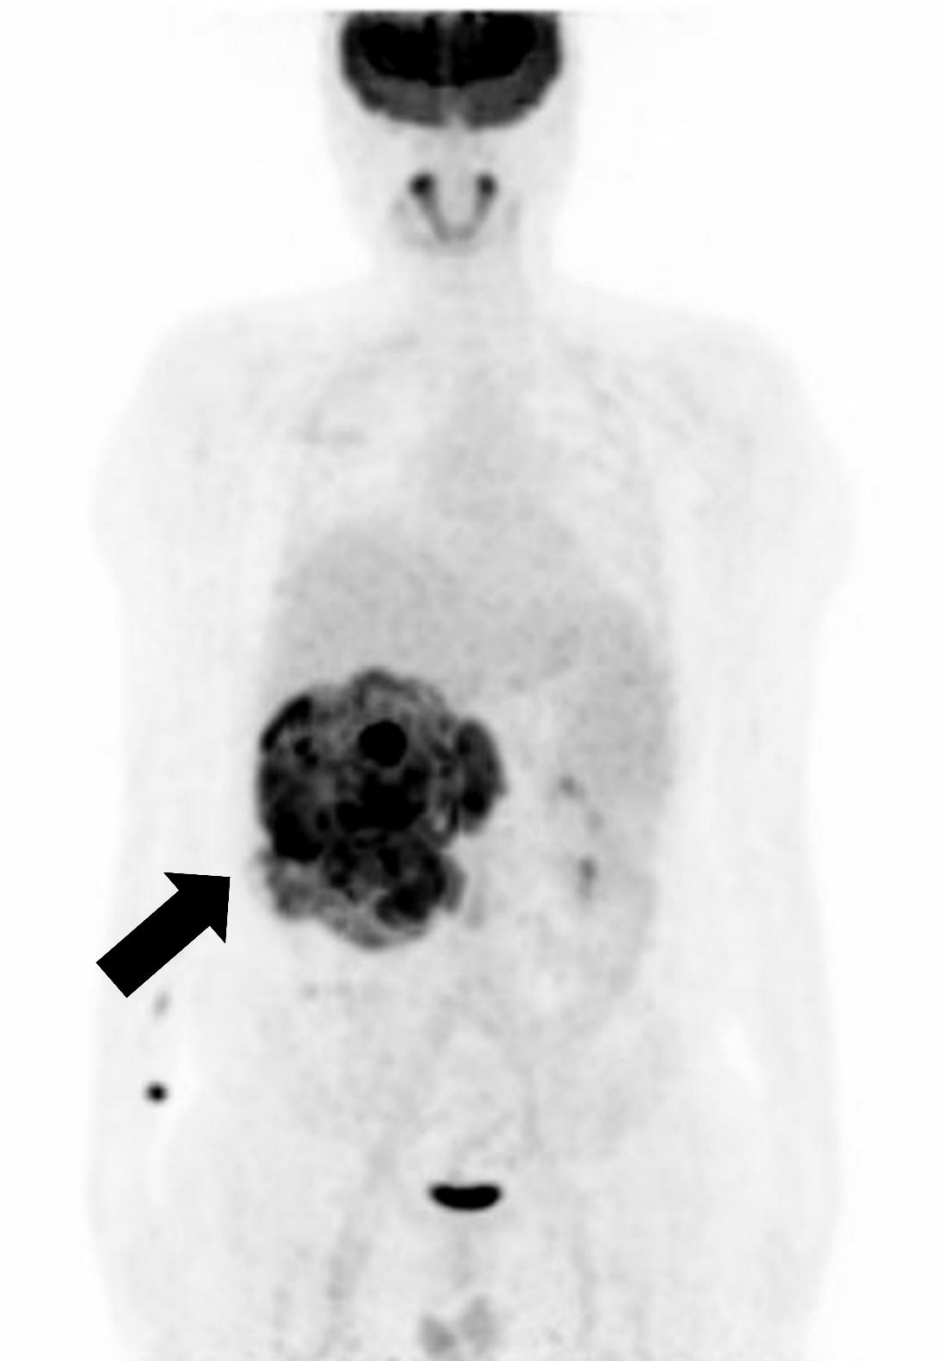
Whole-body positron emission tomography/computed tomography, anterior-posterior view, of this patient, showing a huge hypermetabolic lesion in the right kidney with maximum standardized uptake values of 13.3 (arrow), consistent with RCC, and involving the proximal ureter. Probable metastatic lymph nodes were detected in the retrocaval and aortocaval areas, along with tumor thrombosis in the right renal vein and inferior vena cava.
